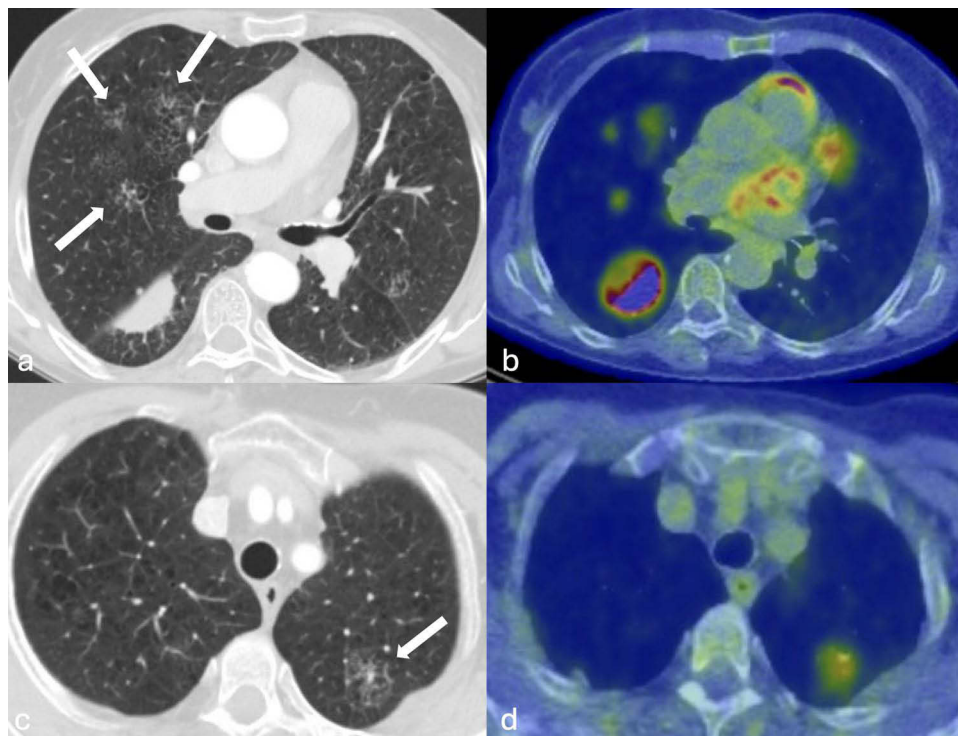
Chest CT demonstrating multifocal subsolid lesions (white arrows) in the right upper lobe (a) and left upper lobe (c), with associated increased FDG uptake on PET-CT (b and d).
